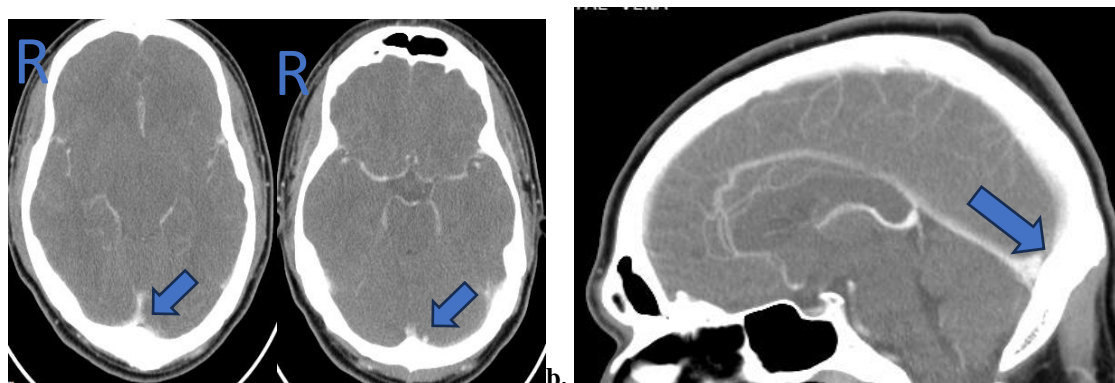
CT Venografi. a. Axial Section (Filling defect sinus transversus) b. Sagittal Section (Filling defect sinus Sagitalis superior)
